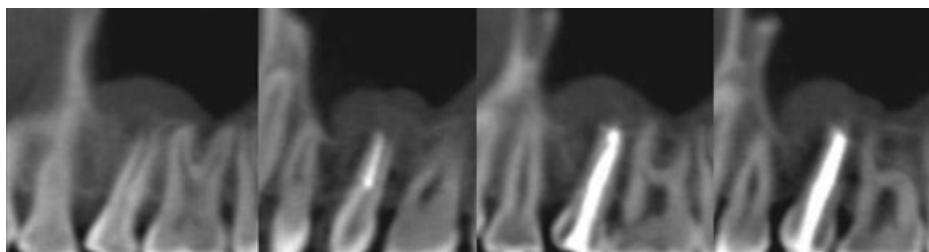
Cone-beam computed tomography reformative sectional view series taken at 5 months after surgery.
